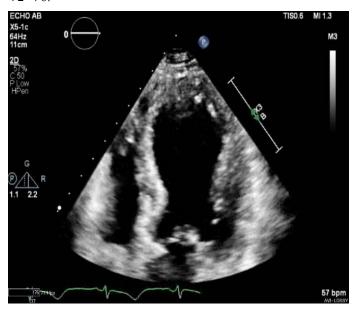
Transthoracic echocardiogram (apical four-chamber view) showing apical ballooning consistent with Takotsubo cardiomyopathy. Left ventricular systolic function is moderately reduced with an estimated ejection fraction of 36% to 40% and there is grade I (mild) diastolic dysfunction. Wall motion abnormalities are suggestive of stress-induced cardiomyopathy
